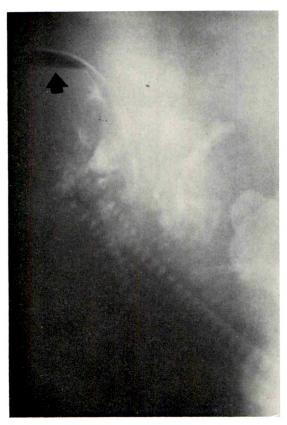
Erect oblique roentgenogram of maternal abdomen. Note gas within the fetal cranium.
